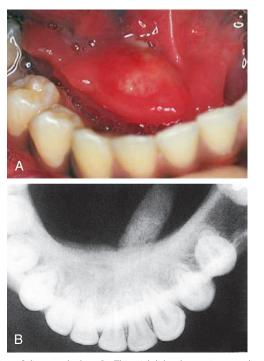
Salivary calculus. A, This sialolith obstructing a salivary duct is observed in the floor of the mouth. B, A dental radiograph of the sublingual space reveals the size and location of the salivary calculus.
